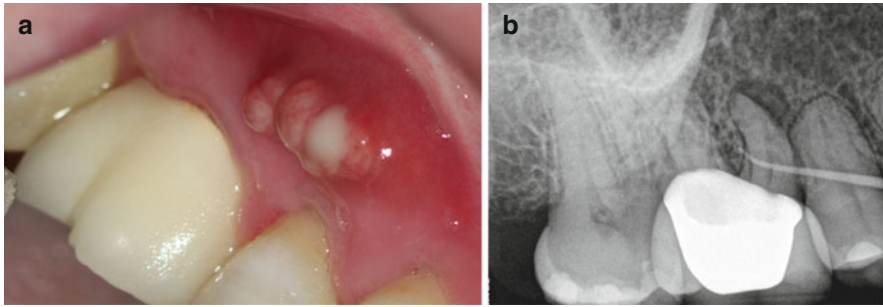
(a) Clinical photography of a sinus tract adjacent to the maxillary second premolar tooth. (b) Radiograph of the same area showing the presence of a gutta-percha tracer in the sinus tract leading toward the periradicular radiolucency associated with the mesial root of the first molar tooth
